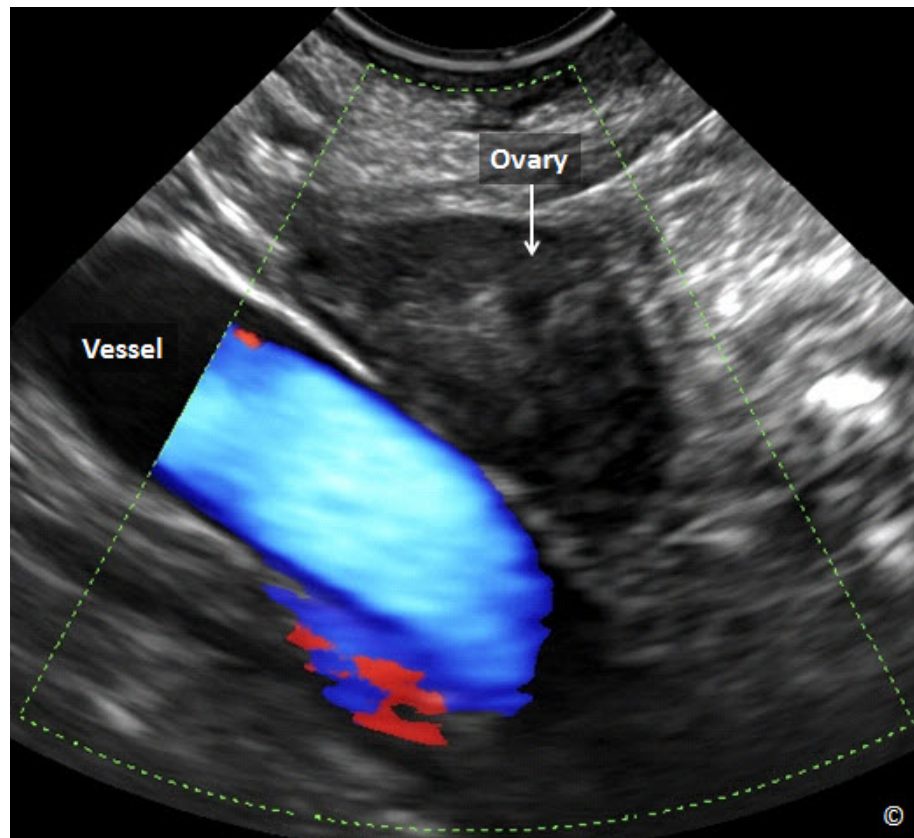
Transvaginal ultrasound of a normal ovary (labeled). Note the anatomic location of the ovary, overlying the hypogastric vein (labeled as vessel).
